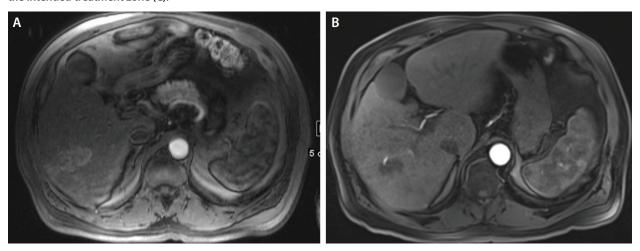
Pretreatment arterial phase MRI abdomen demonstrating 4.5-cm segment 6 HCC (A). Eight-week posttreatment arterial phase MRI of the abdomen demonstrating a nonenhancing treated lesion in segment 6 (B).
